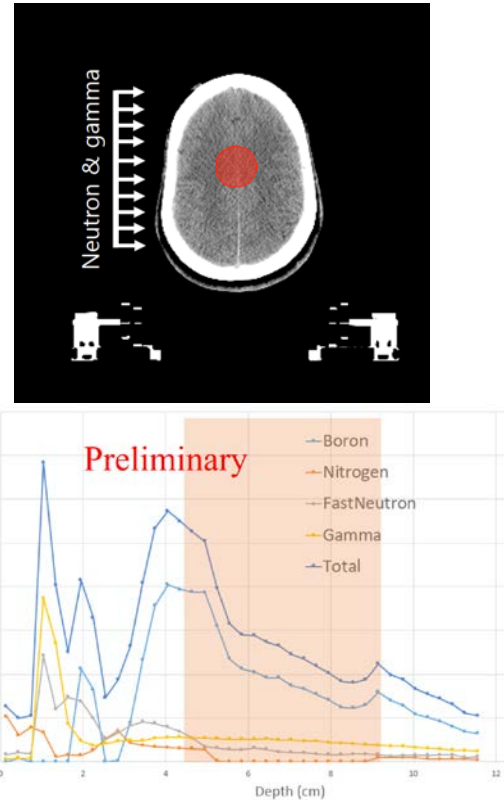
DICOM CT image, the red circle is tumor region (top), the weighted depth dose along the beam axis (bottom).
